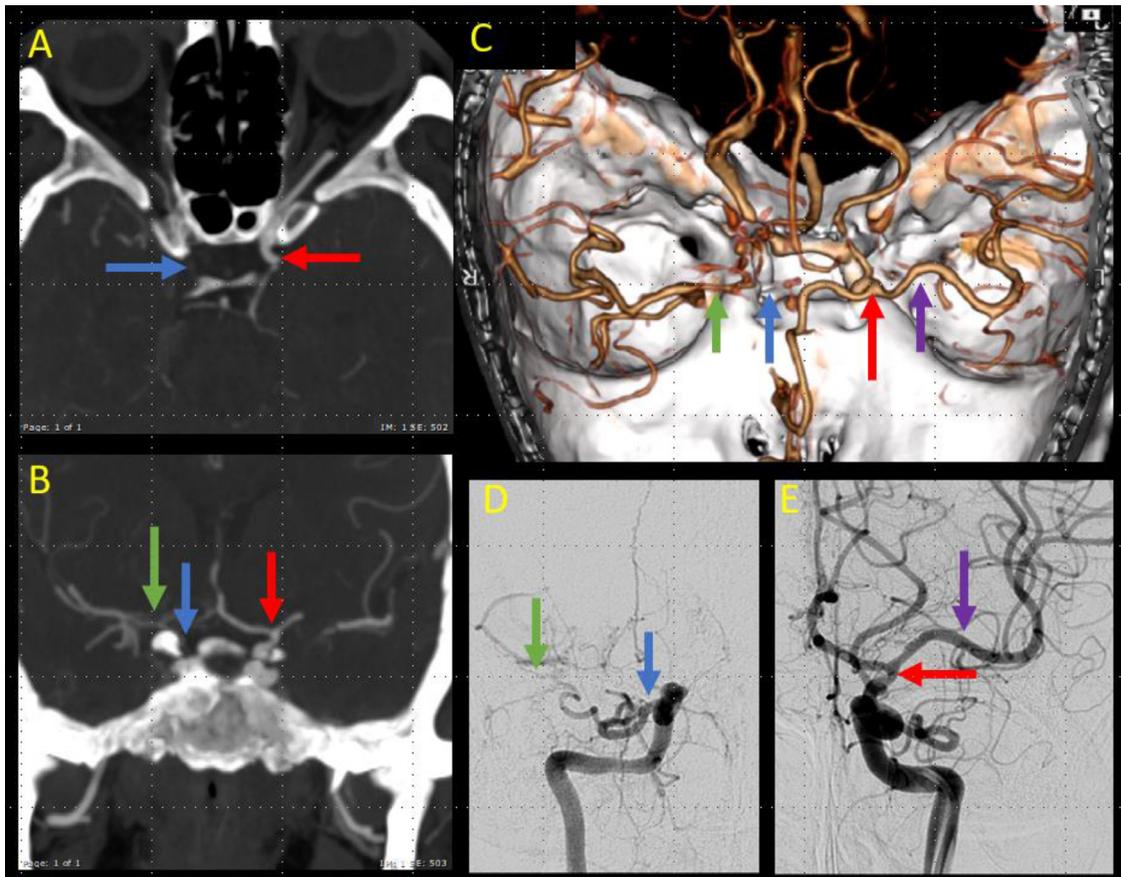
Computerized tomography angiography (CTA) and angiography with stenotic internal carotid artery (ICA); axial (A), coronal (B) CTA maximum intensity projection images; 3-dimensional volume-rendered CTA reformat (C); and AP projections from right (D) and left (E) selective ICA injections from a digital subtraction angiogram demonstrate an occluded right supraclinoid ICA (blue arrow) and small caliber right middle cerebral artery (green arrow) compared to the patent contralateral left supraclinoid ICA at the carotid terminus (red arrow) and normal caliber left Middle cerebral artery (MCA) (purple arrow).
